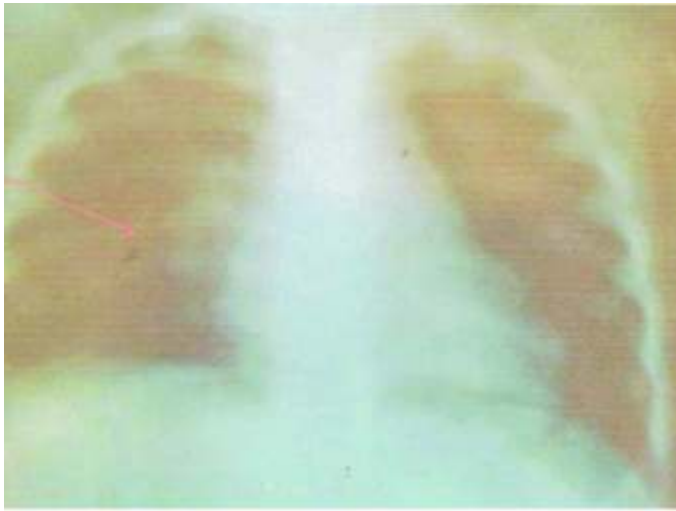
Chest Radiograph, showing hilar adenopathy and opacities
